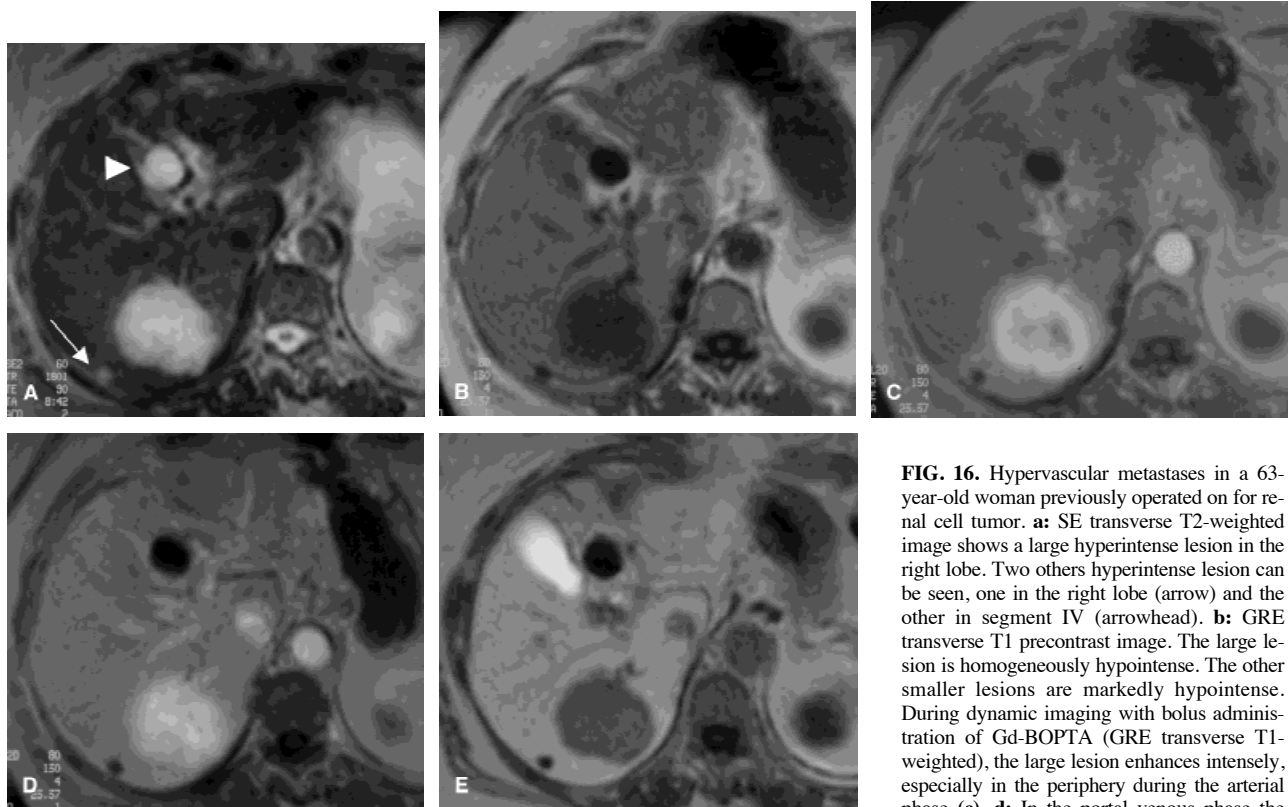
Hypervascular metastases in a 63-year-old woman previously operated on for renal cell tumor. a: SE transverse T2-weighted image shows a large hyperintense lesion in the right lobe. Two others hyperintense lesion can be seen, one in the right lobe (arrow) and the other in segment IV (arrowhead). b: GRE transverse T1 precontrast image. The large lesion is homogeneously hypointense. The other smaller lesions are markedly hypointense. During dynamic imaging with bolus administration of Gd-BOPTA (GRE transverse T1-weighted), the large lesion enhances intensely, especially in the periphery during the arterial phase (c). d: In the portal venous phase the lesion is homogeneously hyperintense. The
